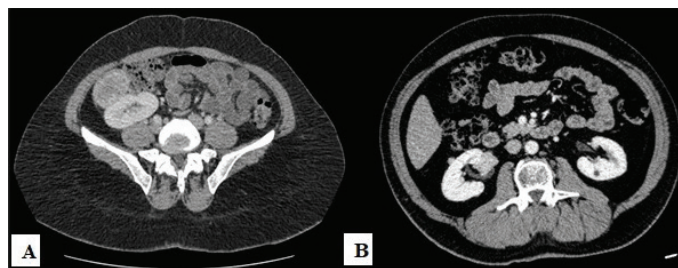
Contrast-enhanced CT images of Case 1 (A) and Case 3 (B)
